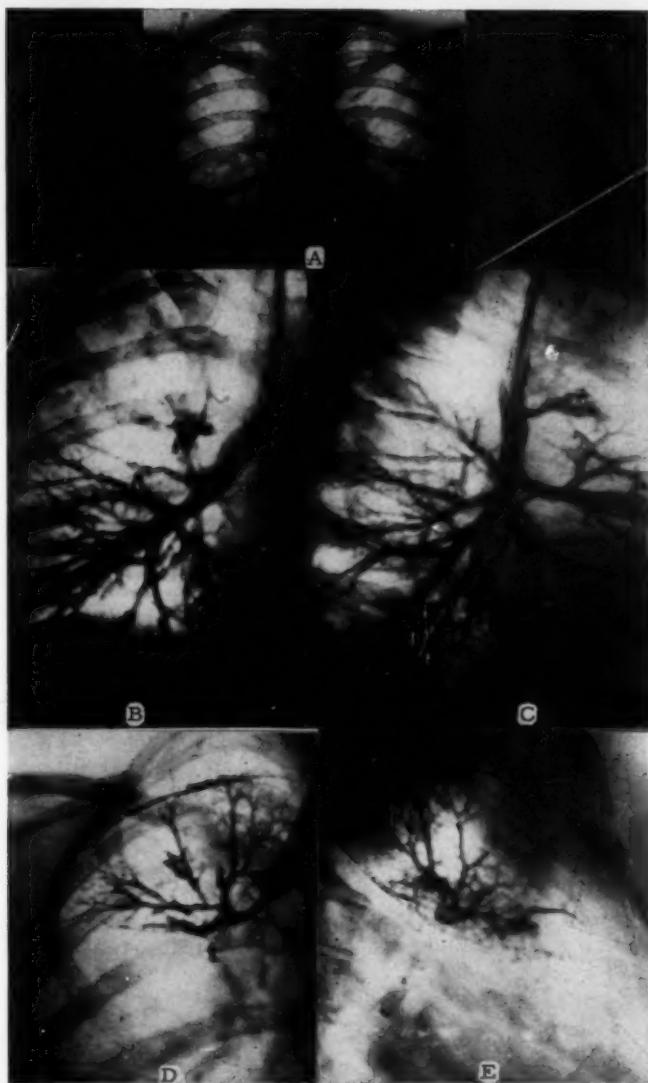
Case 5: AP roentgenogram (A) shows no abnormal density in the suspected right upper lobe region. In AP and lateral bronchograms (B and C) filling of the right upper lobe bronchi was prevented by extreme cicatricial stenosis of the right upper lobe bronchus caused by tuberculous bronchitis.
